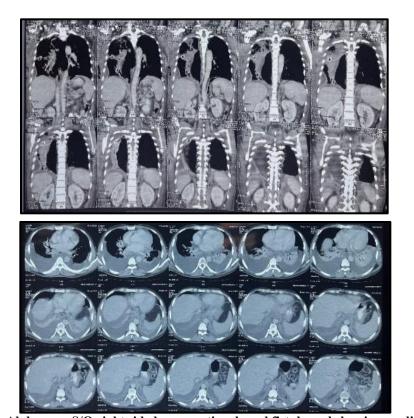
CT Thrax & Abdomen-S/O right sided pancreaticopleural fistula and showing mediastinal collection.
